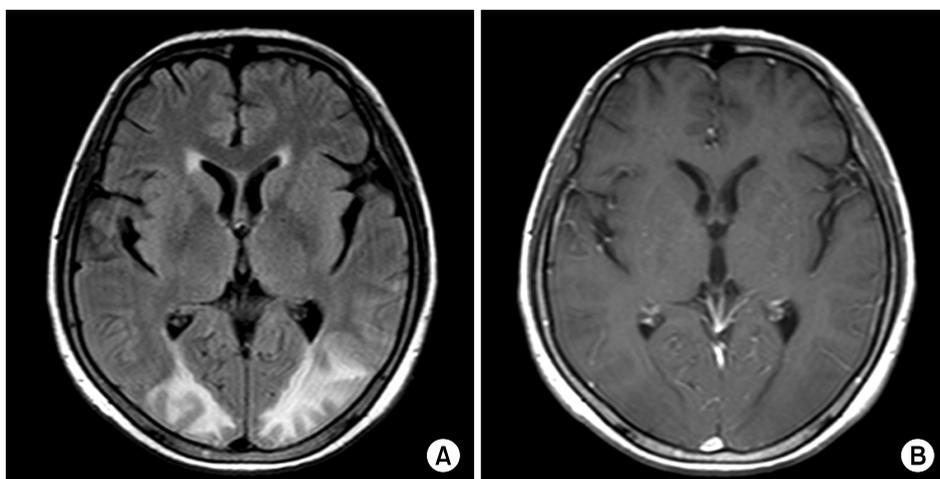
MRI. (A) Fluid-attenuated inversion-recovery (FLAIR), white hyperintensity in the occipital white matter. (B) Gadolinium enhanced image, no enhanced area on same area.
